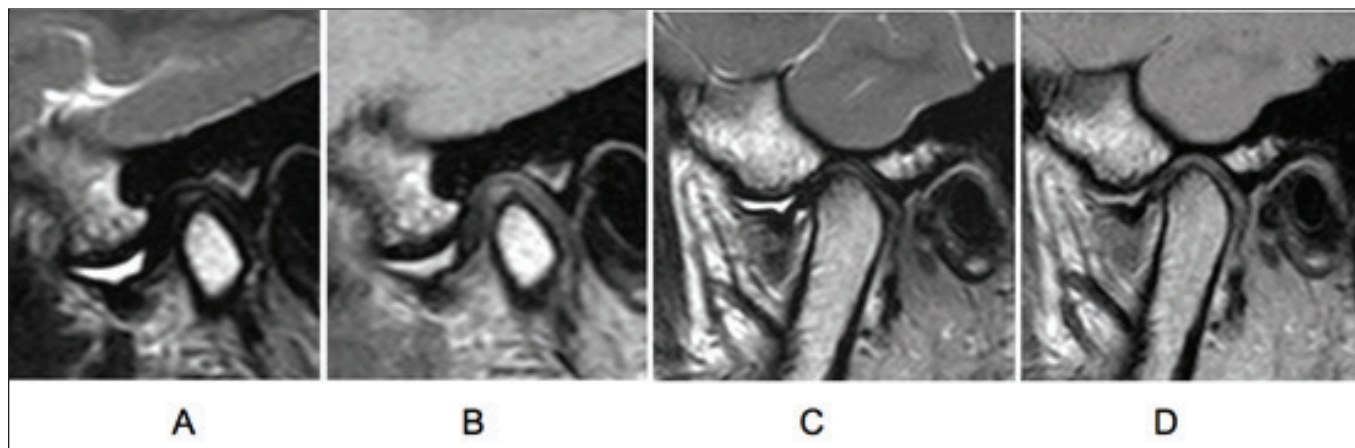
Joint Effusion on T2 (A-C) and PD (B-D) weighted Magnetic Resonance Imaging. Figure shows presence of Joint effusion in upper anterior disk space at close mouth. Image correspond to a left TMJ of a 14 years old, female patients.
